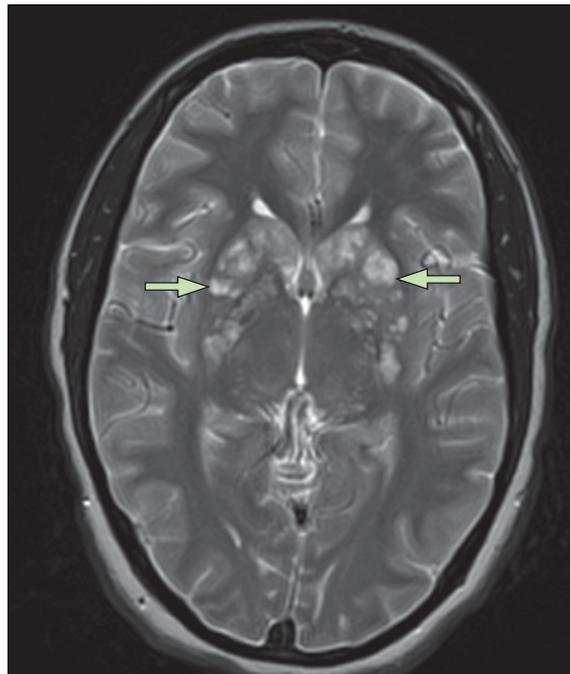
T2-weighted axial images demonstrating hyperintense lesions (arrows) at the basal ganglia consistent with multiple gelatinous pseudocysts in the perivascular spaces (dilated Virchow-Robin spaces with mucoid capsular material of *Cryptococcus* spp)
